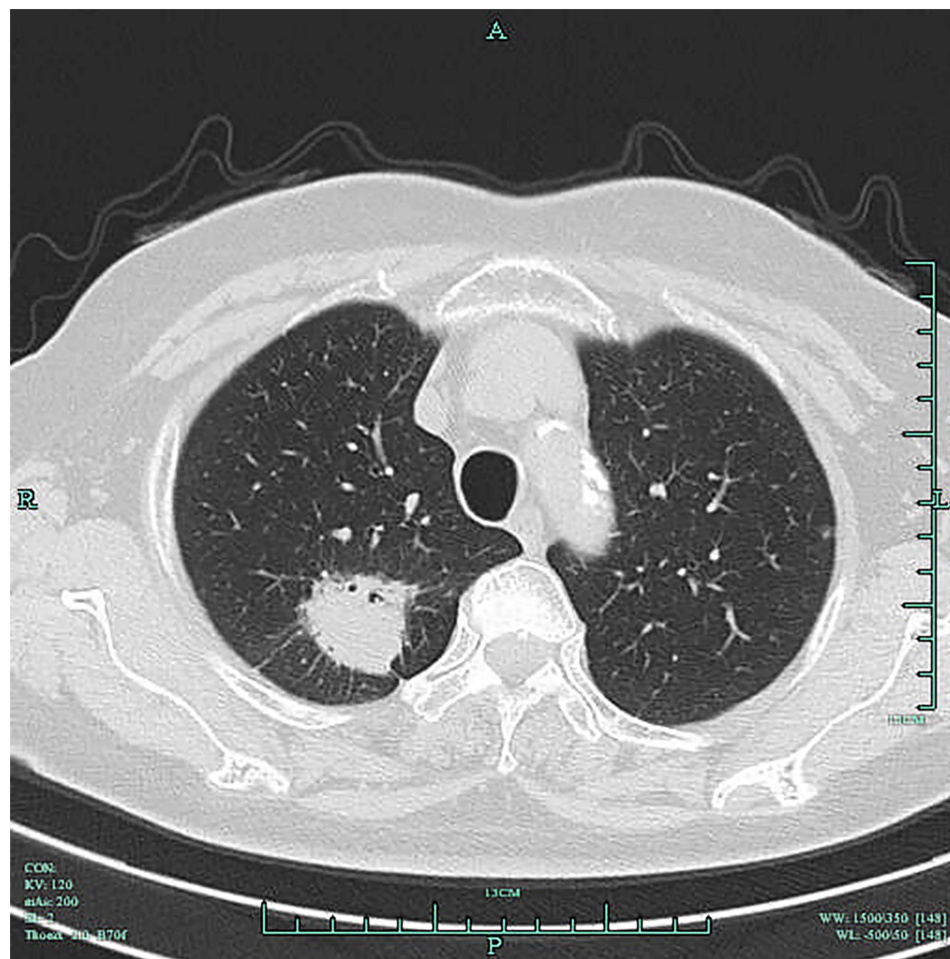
CT signs of low-dose spiral CT in patients with malignant lesions.
